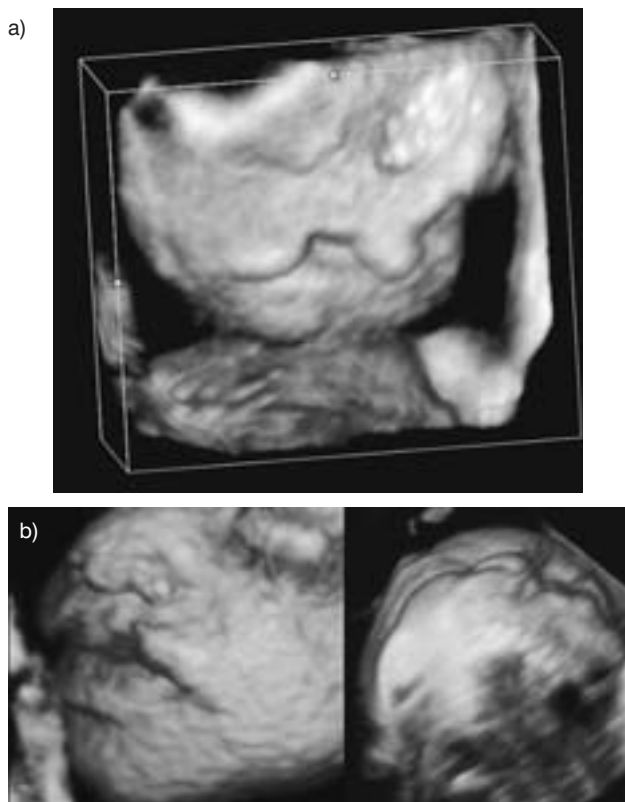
Cleft lip associated with holoprosencephaly diagnosed by 3D ultrasound at 14 (a) and 21 (b) weeks of gestation. a) cleft lip and cleft alveolar ridge at 14 weeks (vaginal probe); b) cleft lip – surface rendering of the face at 21 weeks
